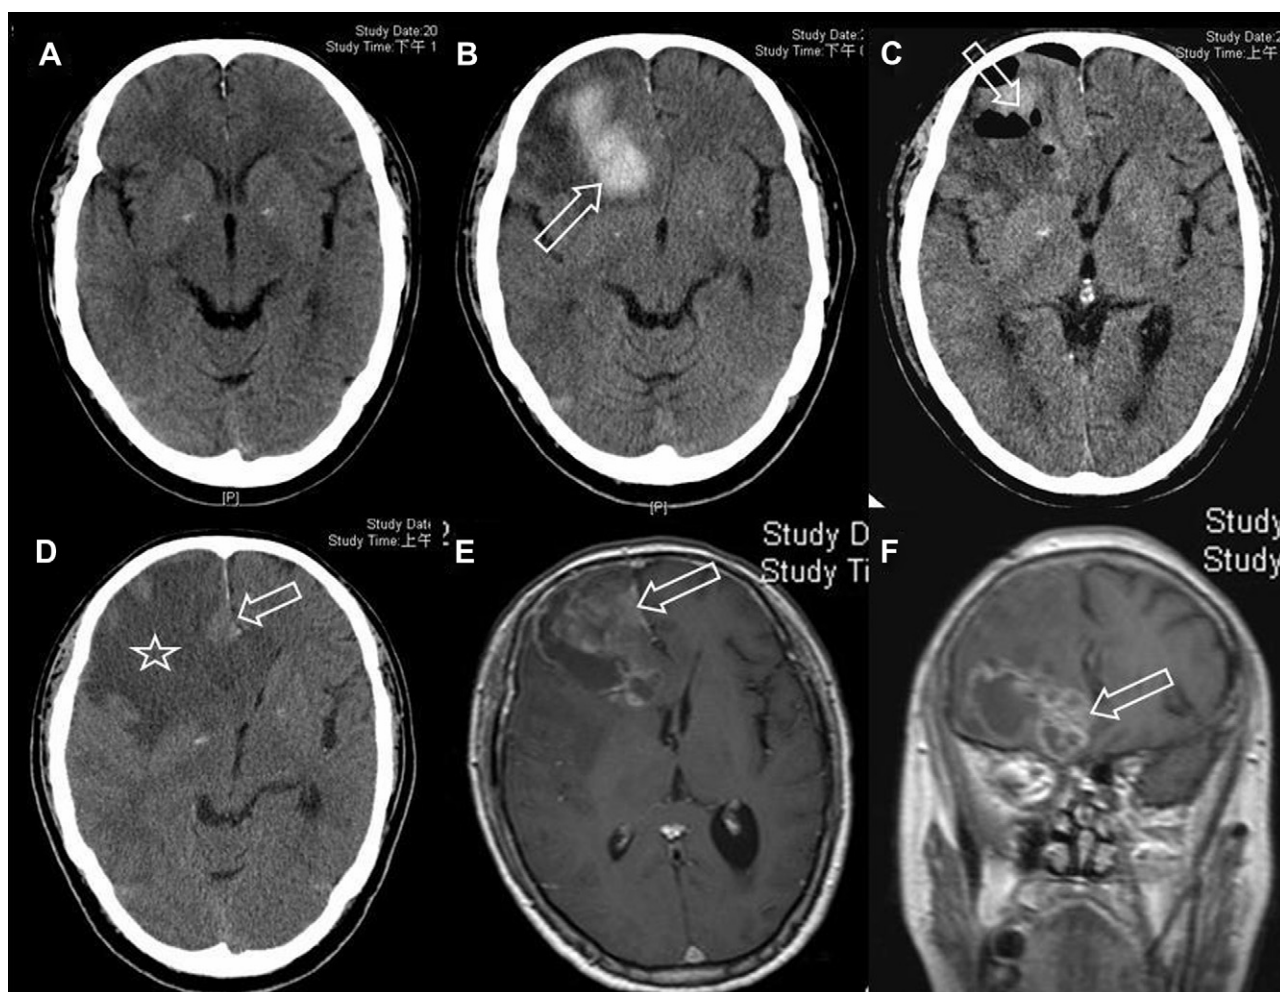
(A) Cranial CT 7 months before diagnosis of GBM. There was no identifiable lesion. (B) Cranial CT 2 months before diagnosis of GBM. There was a resolving right frontal subcortical ICH (arrow) with perifocal edema and subfalcine herniation. (C) Postoperative CT after stereotactic aspiration of the ICH. Procedures were performed by targeting the center of the hematoma (arrow). (D) Cranial CT 2 months after stereotactic aspiration. Diffuse hypodense changes in the right frontal lobe were observed (star), and a mass effect can also be seen (arrow, subfalcine herniation). (E, F) Brain MRI demonstrated a heterogeneously enhanced lesion with an irregular margin in the right mesial frontal area (arrow). CT = computed tomography; GBM = glioblastoma multiforme; ICH = intracerebral hemorrhage; MRI = magnetic resonance imaging.
